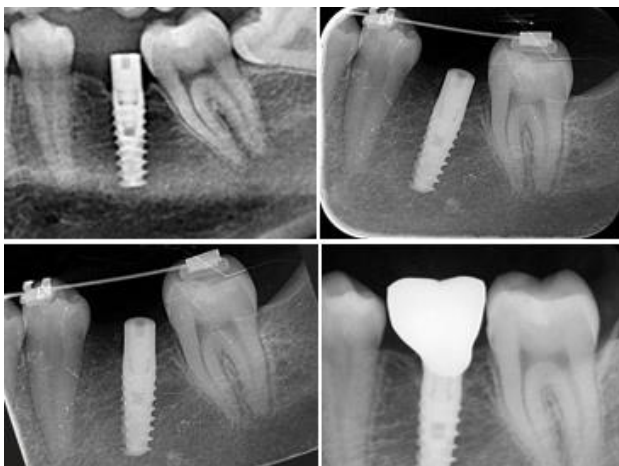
Intraoral Periapical radiograph (IOPA) of Pre-treatment, during uprighting, post treatment and 1 year post retention with crown
